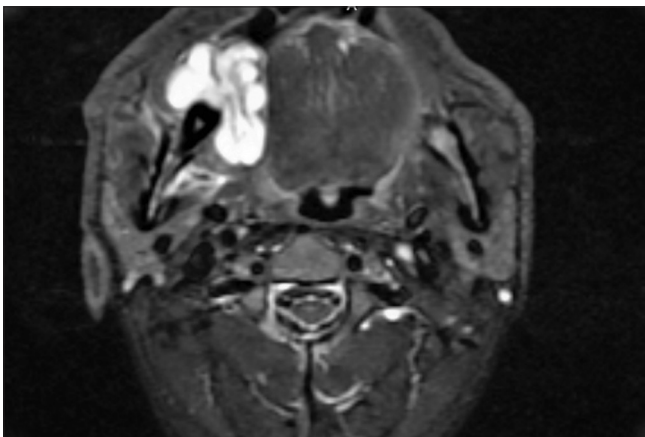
MRI neck showing a heterogeneous, predominantly fluid intensity oral cavity lesion, involving the right mandibular alveolus. MRI: Magnetic resonance imaging
